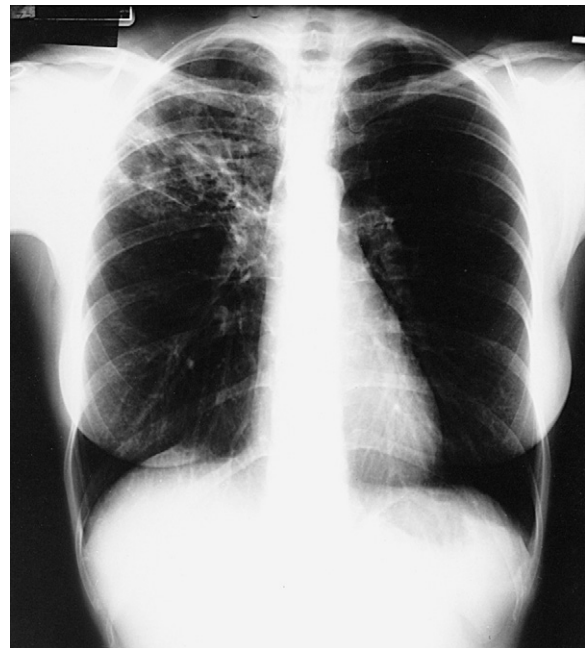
Chest radiograph showing right apical infiltrate typical of a patient with primary tuberculosis.
